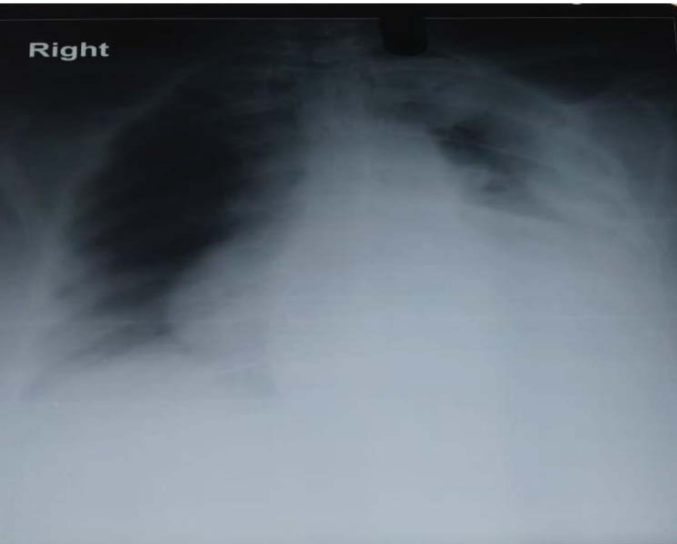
X-RAY Chest showing left hemothorax
